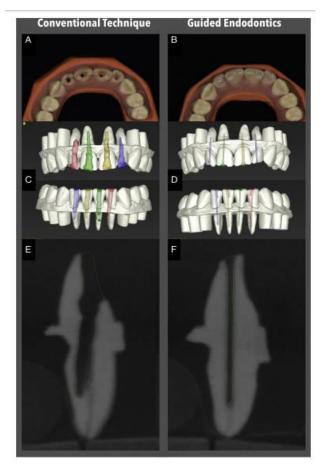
An attempt to locate root canals through traditional approach results in higher tooth substance loss whereas in guided approach, canal location is much more precise, guided by CBCT with lower risk of iatrogenic damage.
